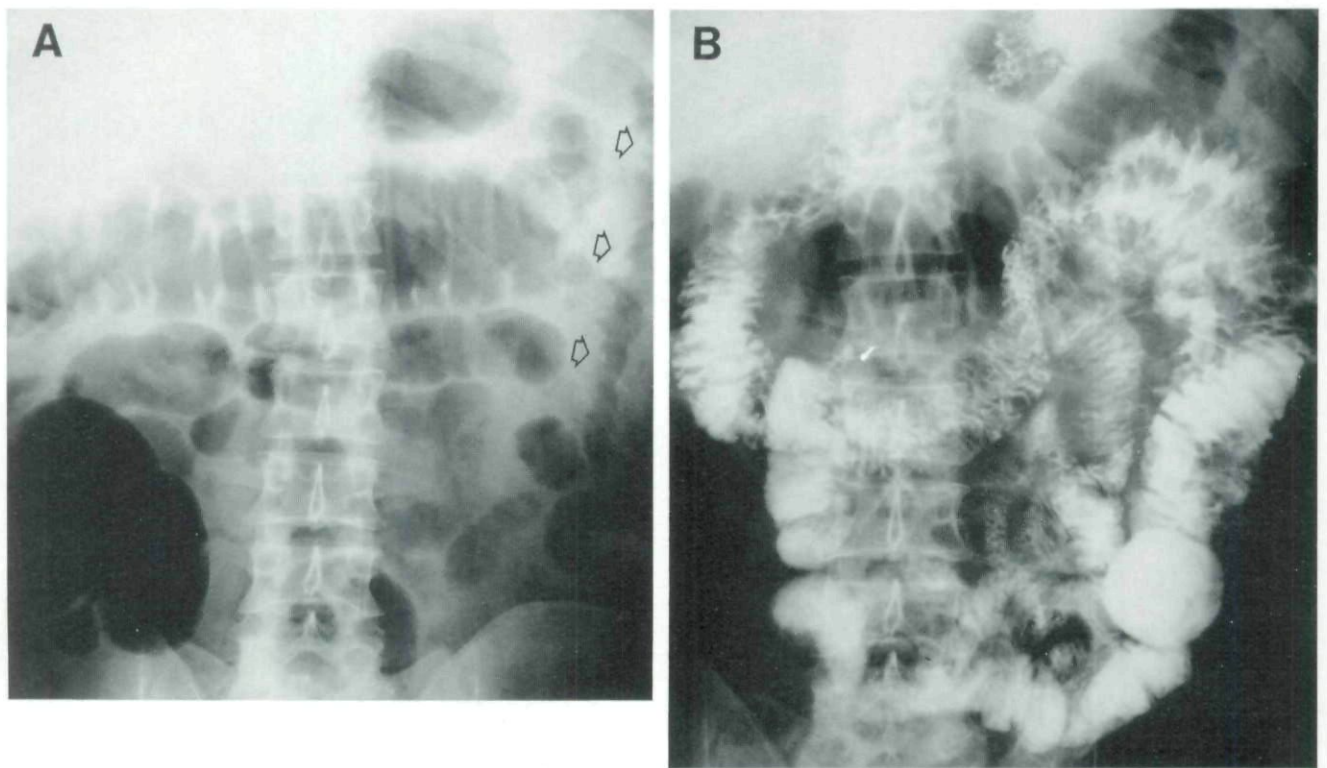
A*, plain abdominal radiograph shows a thickened edematous loop of small bowel in the left upper quadrant with "thumbprinting" indicating submucosal infiltration (*arrows*). *B*, a small bowel examination shows mucosal thickening and edematous loops of jejunum and proximal small bowel with no evidence of obstruction or mass lesion.
